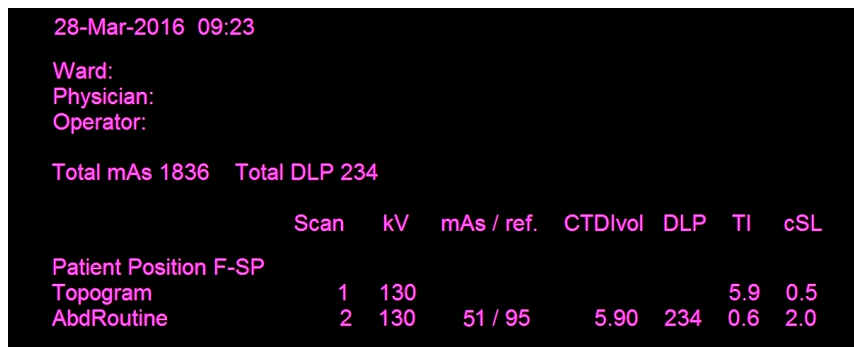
Captured CT dose summary from Siemens Somatom Emotion 6 showing the $CTDI_{vol}$, DLP, mAs, and reference tube current (ref) for the scan range. The rotation time (TI) and collimated slice thickness (cSL) are also shown.
